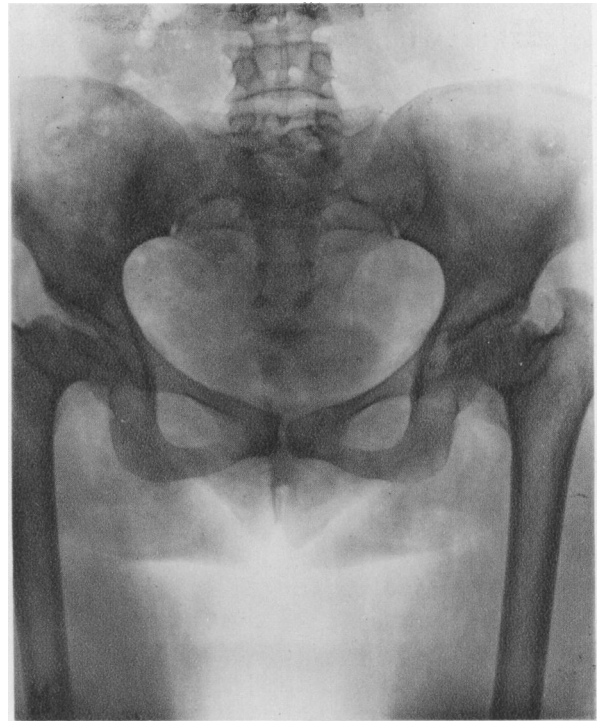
Mother, aged 44. Radiograph showing absence of head of femur and thickening of necks.
